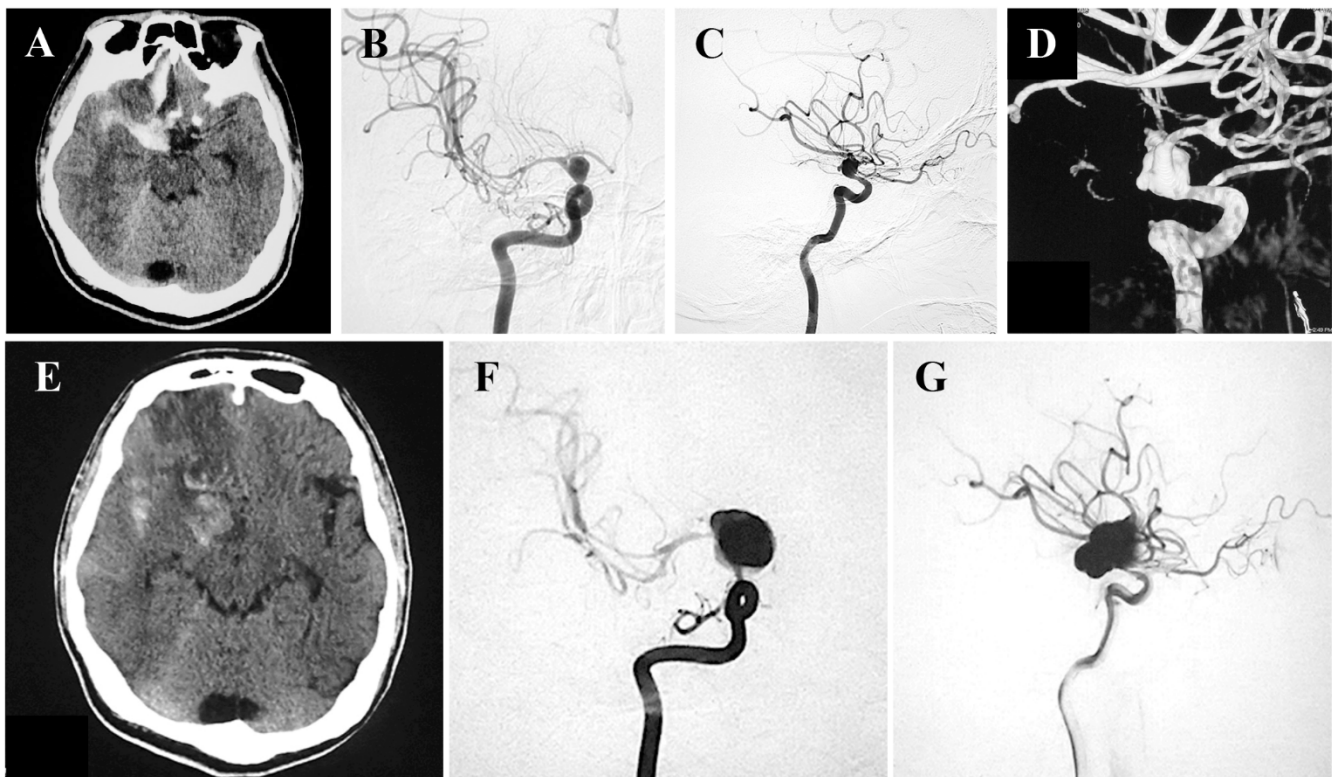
Unenhanced axial CT scan and DSA (A–D) at onset in the previous hospital and (E–G) at the time of rerupture at our institution. (A) CT showed subarachnoid hemorrhage and intracranial hemorrhage in the right frontal lobe. A bleeding source was identified in the right ICA dissecting aneurysm on (B, C) DSA and (D) three-dimensional DSA. Three-dimensional DSA showed irregular vessel dilatation exhibiting the string-of-pearls sign from the ICA (C2 portion) to the middle cerebral artery (M1 portion). (E–G) On DSA, the ruptured dissecting ICA aneurysm appeared larger. CT, computed tomography; DSA, digital subtraction angiography; ICA, internal carotid artery.
